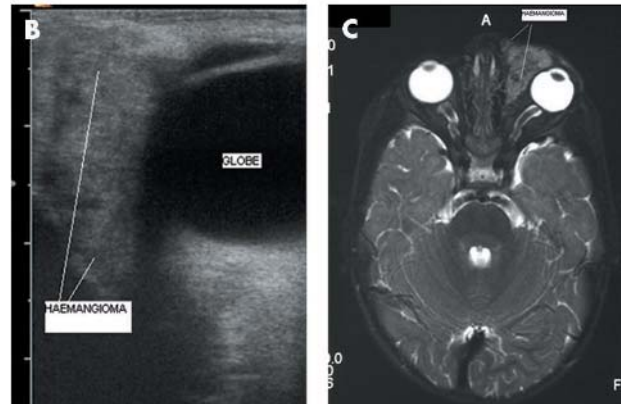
(A) Clinical photograph of a deep periocular haemangioma. (B) A vertical ultrasound scan of the case shown (A). Again the left of the picture corresponds to the superior part and the right to the inferior part of the orbits. The haemangioma extends into the extraconal portion of the orbit. (C) Axial MRI of the case shown in (A). The haemangioma is seen to be preseptal and extraconal confirming the ultrasound findings. (Reproduced with the parents' permission.)
